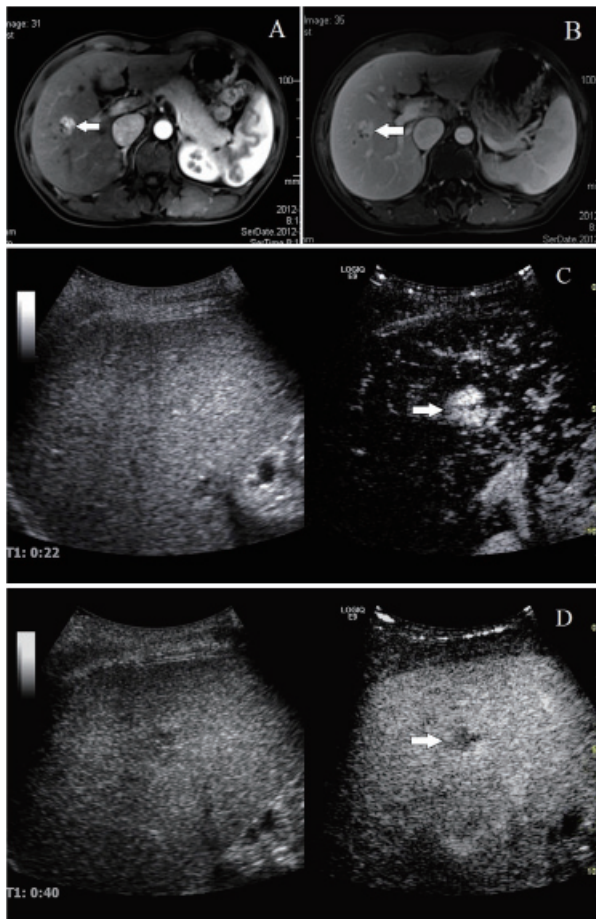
Liver hemangiomas on CEMRI, but malignant tumor on CEUS. (A) MRI: Peripheral enhancement with centripetal filling in the arterial phase (arrow). (B) MRI: High signal intensity with low-intensity signals from vascular structure in the portal venous phase (arrow). (C) CEUS: Diffuse enhancement in the arterial phase with fast filling (arrow). (D) CEUS: Hypoechoic change in the arterial phase (arrow).
